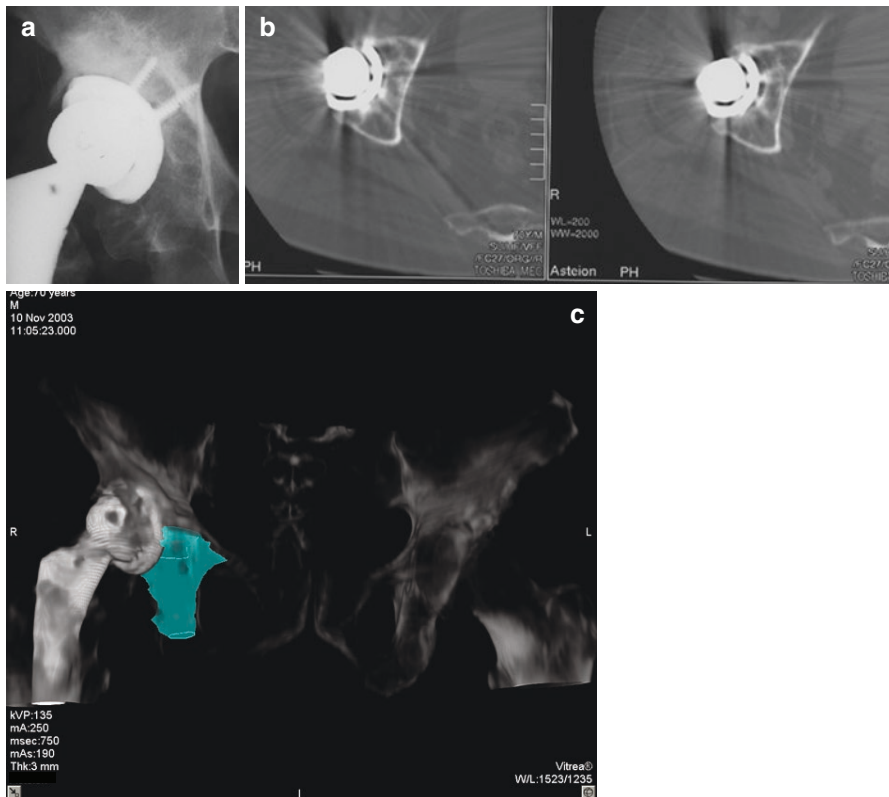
(a) An anteroposterior radiograph of a 70-year-old man seven years postsurgery shows an expansile and contained lytic cavity around a stable cementless cup. (b) A CT image shows a lytic cavity around the cup. (c) Multislice CT reconstruction shows a lytic cavity (in green) increasing the size of the radiographic preoperative bone defect
